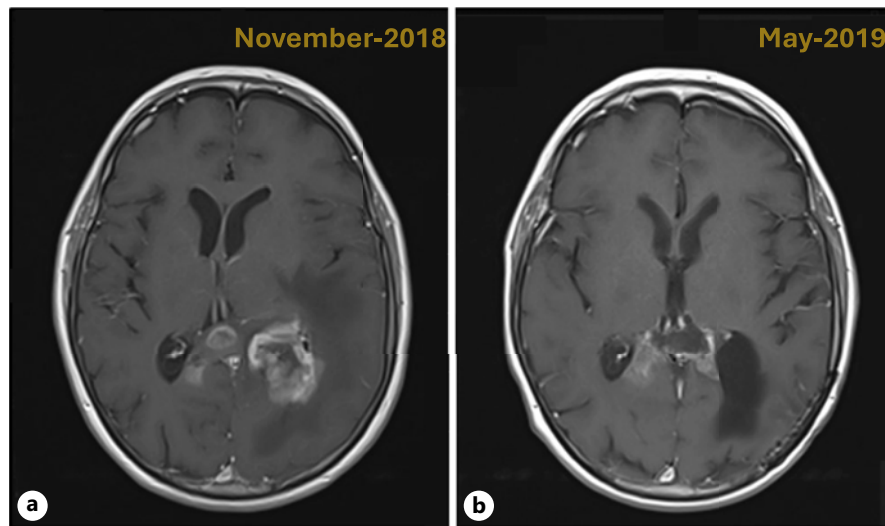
Pre- and postoperative contrast-enhanced T1-weighting MRI scans. a Preoperative MRI taken at baseline (November 2018) and peritumoral edema. b Postoperative MRI taken in May 2019.
